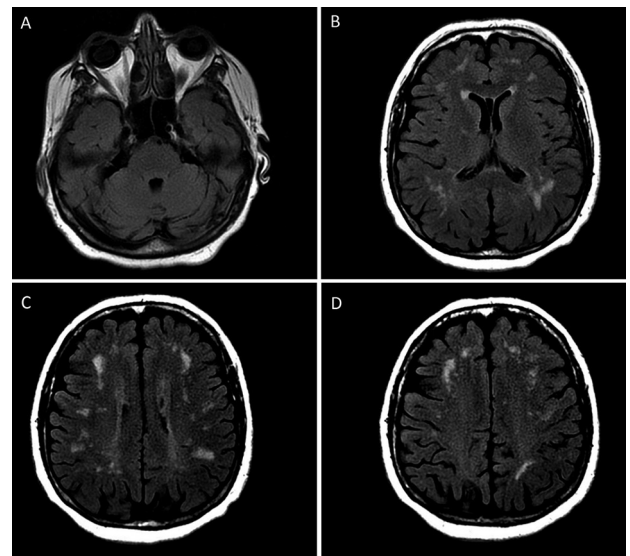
Magnetic resonance images.
